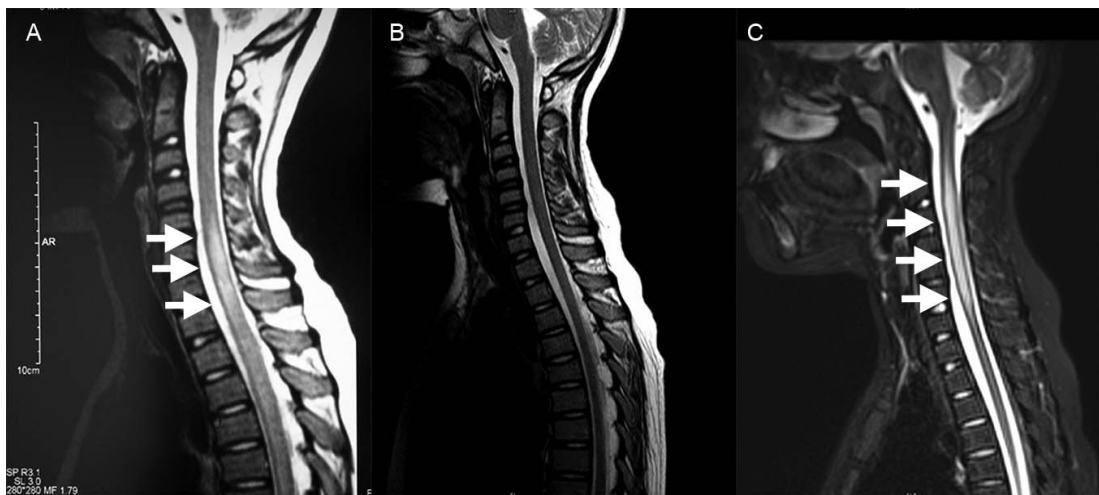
Serial sagittal T2 weighted MRI spinal cord images from an 8 year old boy with relapsing-neuromyelitis optica. (A), longitudinally extensive spinal cord lesion extending from C6-T8 vertebral region (white arrows), during his first presentation. (B), the spinal cord appears normal during his first relapse, an isolated optic nerve presentation, at 8 months from first disease. (C), a contiguous spinal cord lesion extending from C3 –T1 vertebral levels during a spinal cord relapse a year later.
